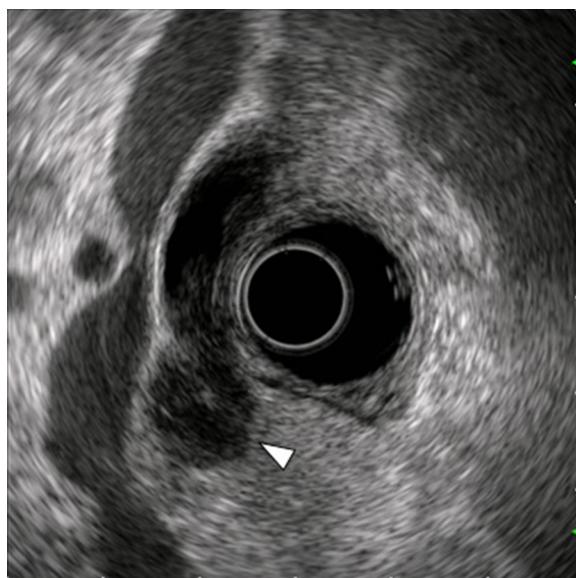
Abbreviations: MANEC, mixed adenoneuroendocrine carcinoma; WHO, World Health Organization; CT, computed tomography; ERCP, endoscopic retrograde cholangiopancreatography; IDUS, intraductal ultrasonography.
